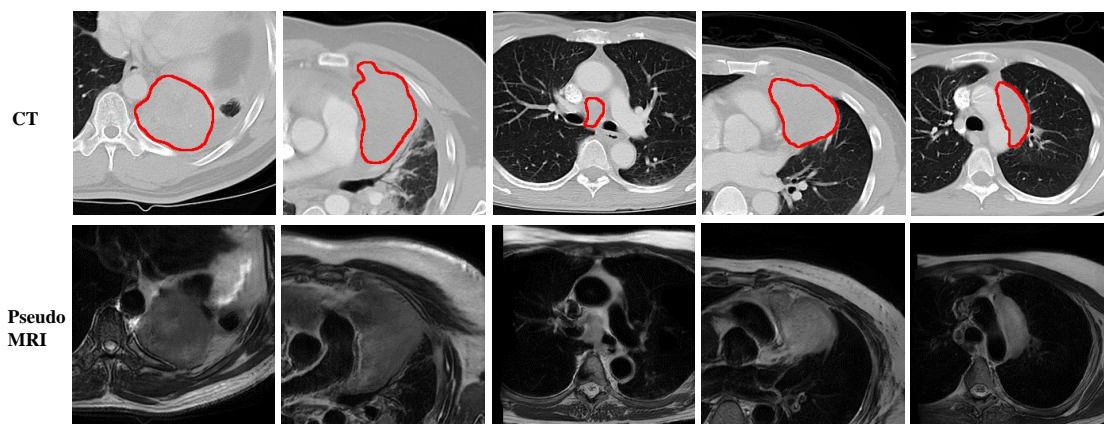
Representative examples of pMRI images translated from CT images using CMEDL. The tumor region is shown by the red contour.
